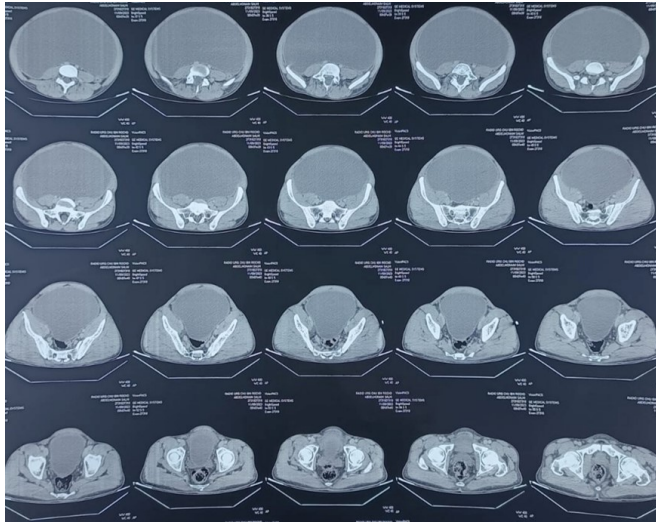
CT scan showing the extension of the abdomino-pelvic cystic mass
